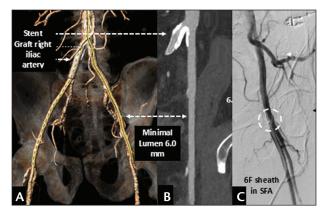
Multislice CT images of the iliofemoral tract demonstrated a stent graft in the right iliac artery (A) and minimal disease but small luminal dimensions (6 mm) in the left iliac artery (B). Digital subtraction imaging demonstrated hemostasis and vessel patency at the 15-F arteriotomy site after plug-based closure with an 18-F Manta vascular closure device (dotted circle, C).
